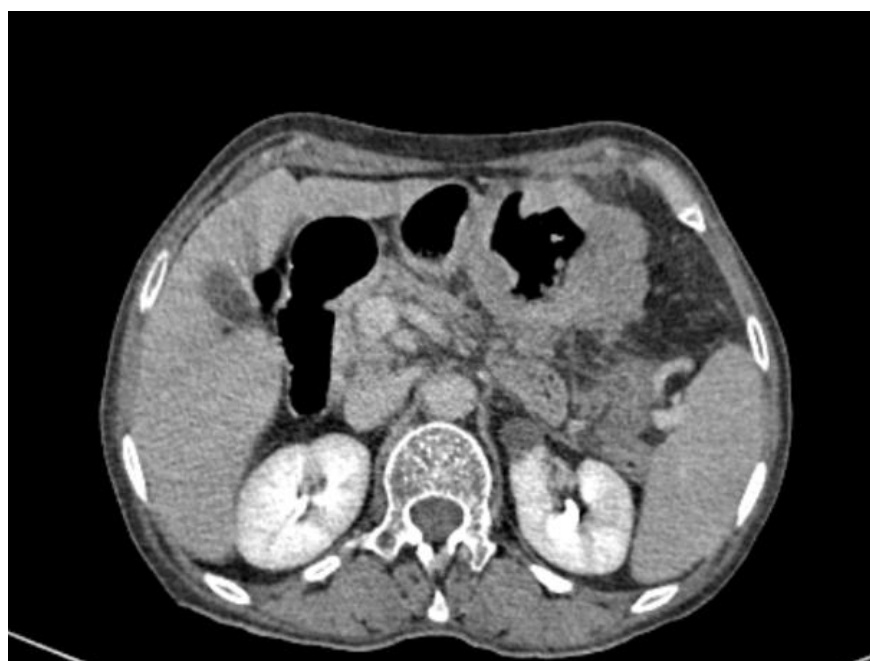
Axial slice of an abdominal CT scan in the delayed phase, showing the splenic nodule corresponding to the metastasis no longer visible.
